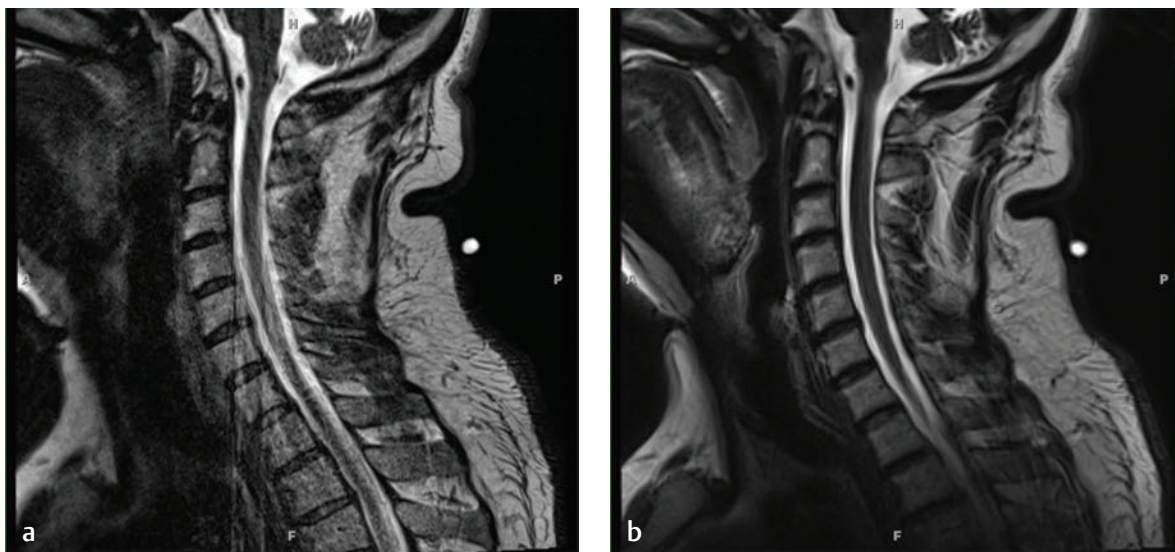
Motion artifact in the cervical spine on sagittal T2-weighted images using 3.0-T MRI in the (a) TSE versus (b) BLADE (Siemens Healthcare) sequences. Motion artifact is substantially reduced as a result of using the BLADE sequence.
